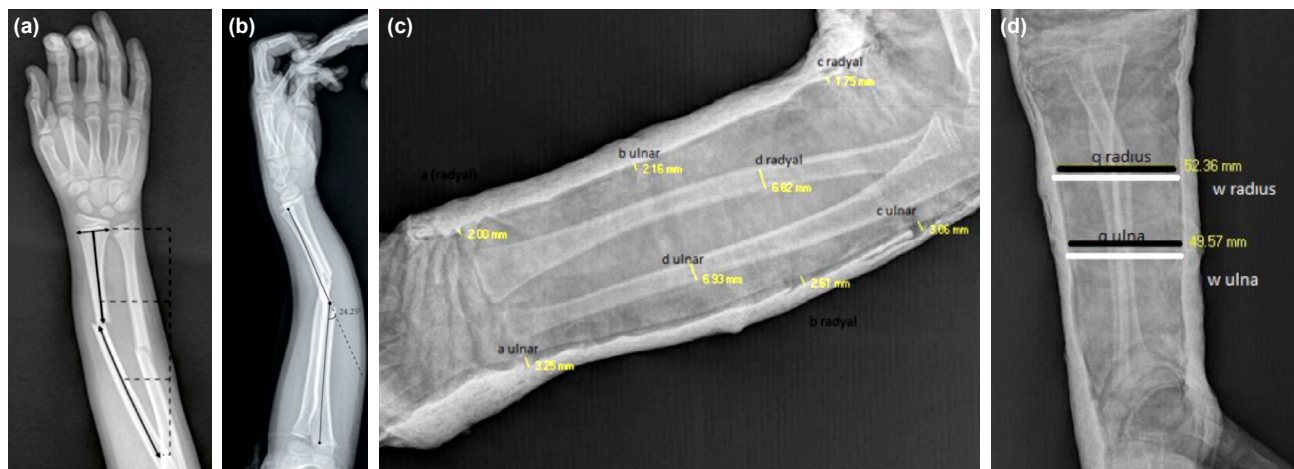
(a) Identification of the fracture location. (b) Angulation on lateral radiography. (c) TPI calculations. (d) CI calculations.
